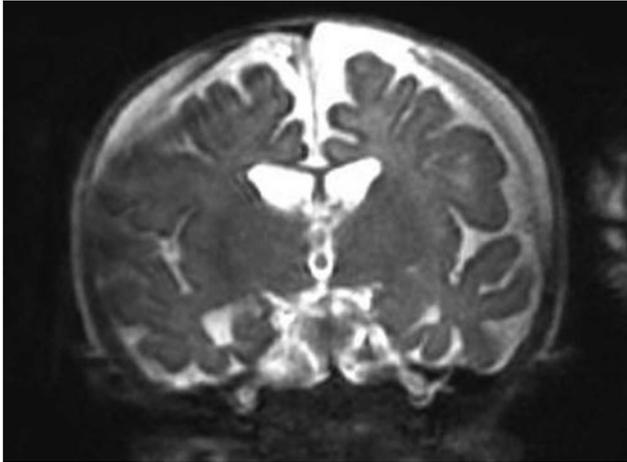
Rapid T2-weighted magnetic resonance (MR) image, coronal view, showing bilateral subdural collections in an infant with an enlarging head. Rapid MR imaging techniques appear to be sensitive in visualizing subdural collections, can be performed without sedation or radiation exposure, and have gained increasing utilization for macrocephaly screening.
